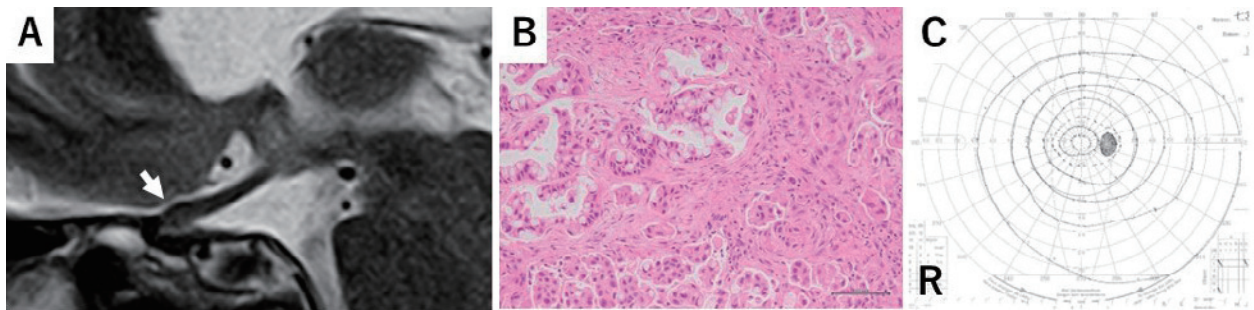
Postoperative sagittal T2-weighted image (A) showing a successful optic nerve decompression. Pathological diagnosis confirmed that the tumor had metastasized from the lung (B). The Goldmann visual field test (C) also demonstrated significant improvements in the patient.
